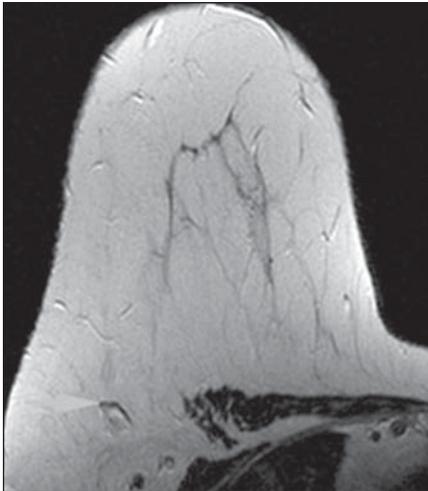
Fat necrosis in 63-year-old woman with history of reduction surgeries and lobular carcinoma in situ who presented for high-risk screening MRI. A, T2-weighted image shows lobulated mass with high signal intensity, isointense with surrounding fatty tissue. B, Loss of signal intensity on fat-suppressed image confirms presence of central fat (*arrowheads*).
